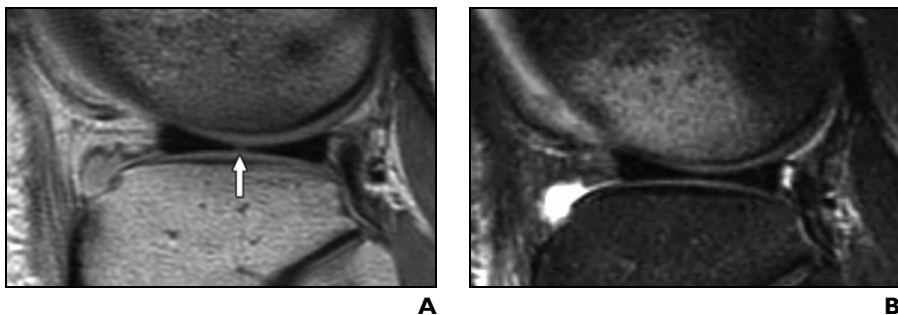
16-year-old boy with originally missed radial tear of body of lateral meniscus that was questionably seen on retrospective review. Tear was trimmed to saucerize lesion. A and B, Sagittal fast spin-echo proton density-weighted (A) and sagittal fat-saturated fast spin-echo T2-weighted (B) images. Tear is seen as subtle area of increased signal intensity on free edge of meniscus (*arrow, A*) in A but is not evident in B. No other sagittal or coronal image depicted meniscal abnormality suggesting tear.
